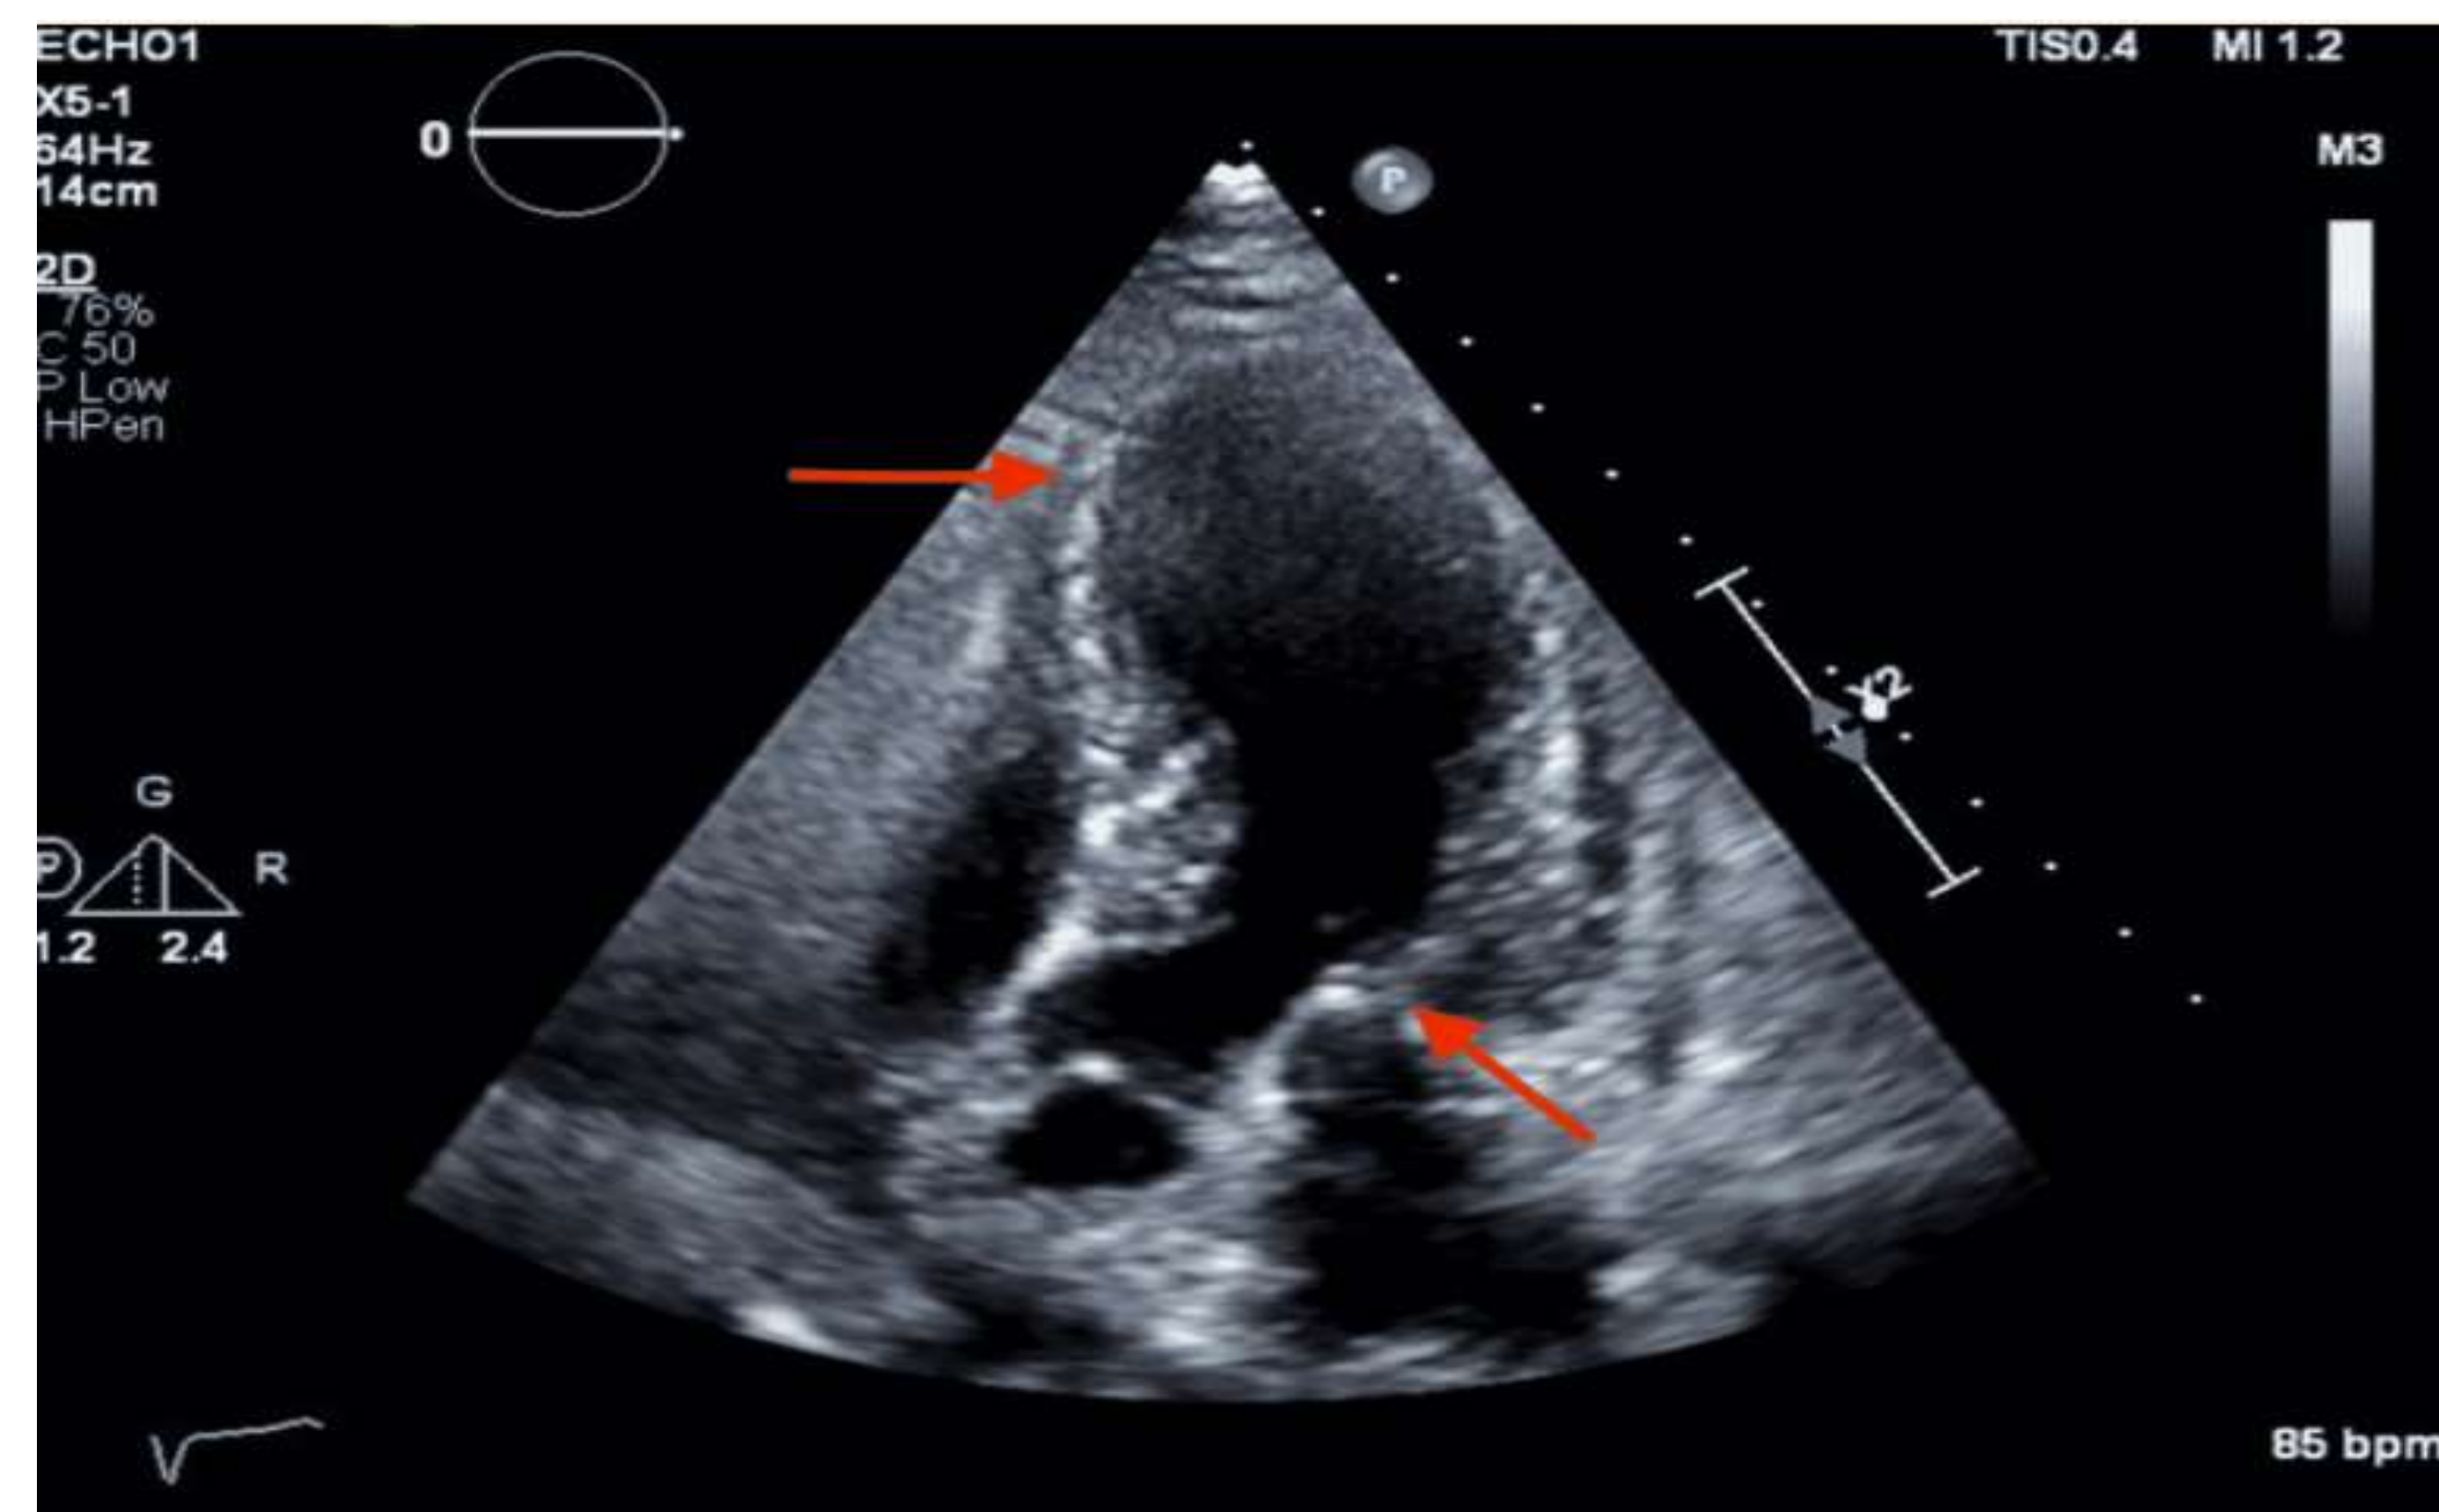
Transthoracic echocardiography showing hypokinetic apex with ballooning with normal basal segments
